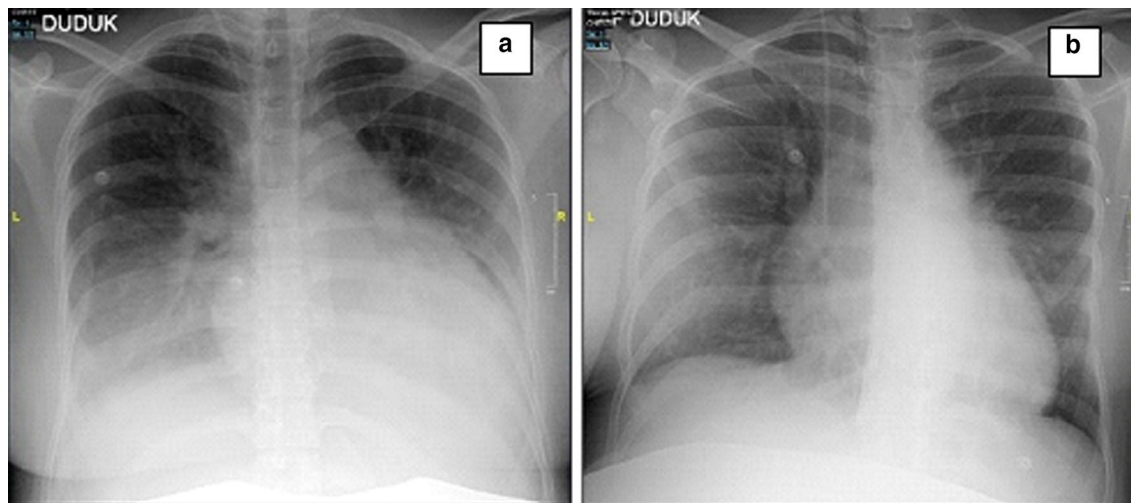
Thorax X-ray during the ninth day a showed worsening cardiomegaly. But compared to the twelfth day (b), cardiac size declined with lesser lung infiltrates as the symptoms subsided
